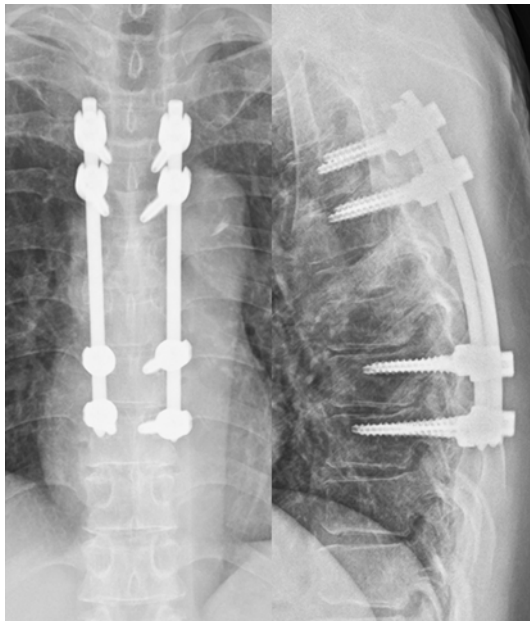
Postoperative X-ray shows T4–9 fixation with percutaneous pedicle screws.
